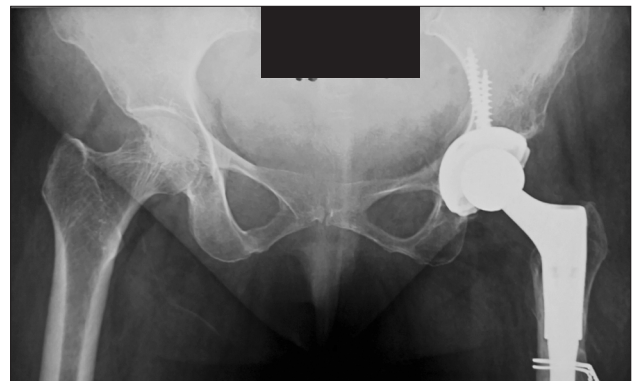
Final follow-up anteroposterior radiograph of patient 2.
